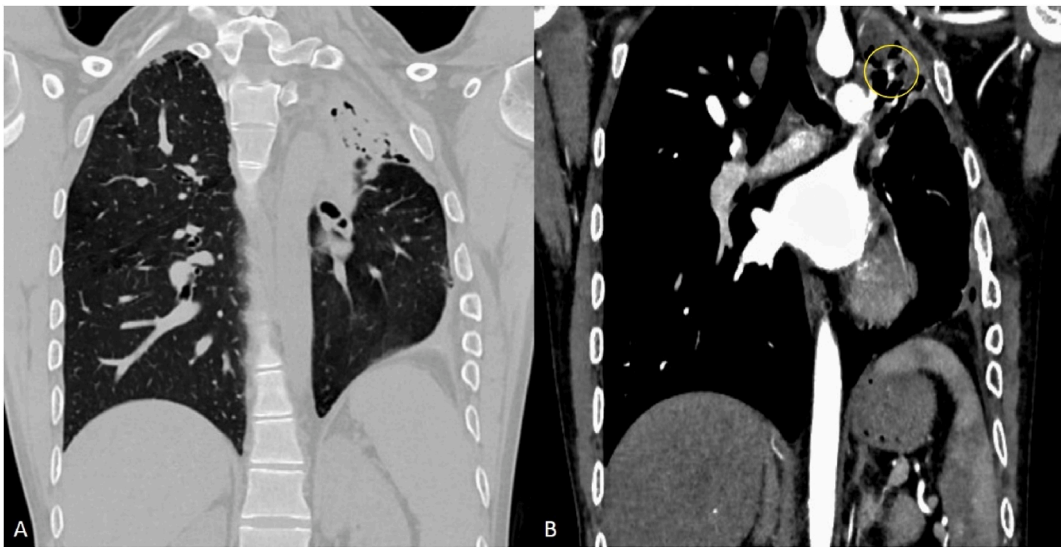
Case 3: CT coronal (A) soft tissue window showing cavitary lung lesion with surrounding fibrotic and bronchiectatic changes in left upper lobe; (B) angiography showing an aneurysm originating from a left upper lobe segmental pulmonary artery branch (encircled).
